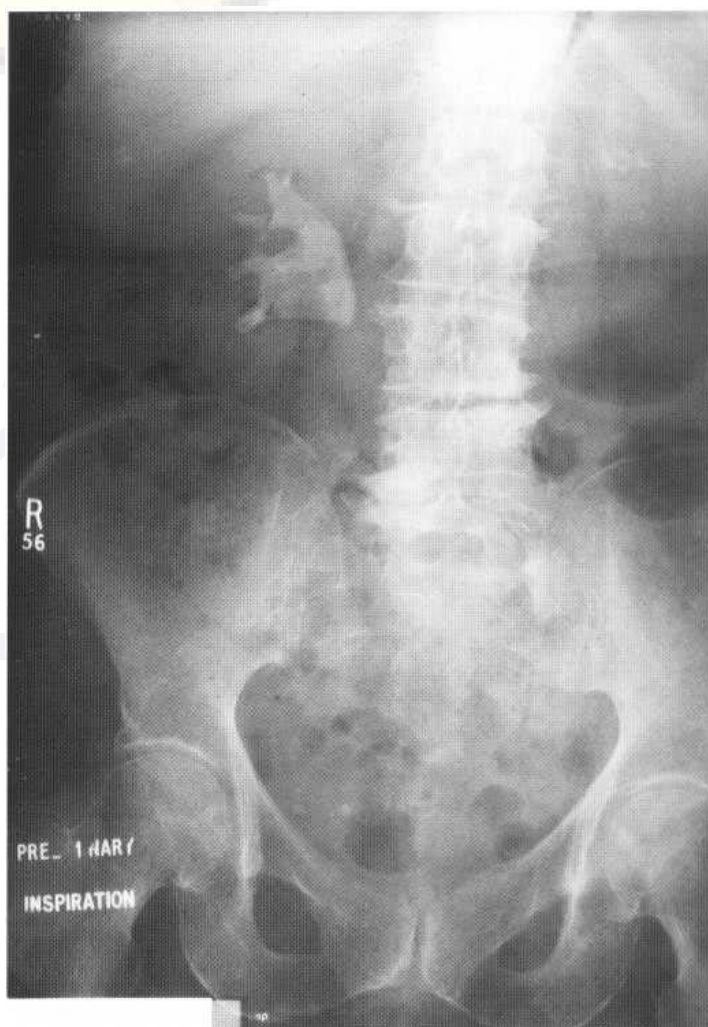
Plain film showing large right staghorn calculus.
